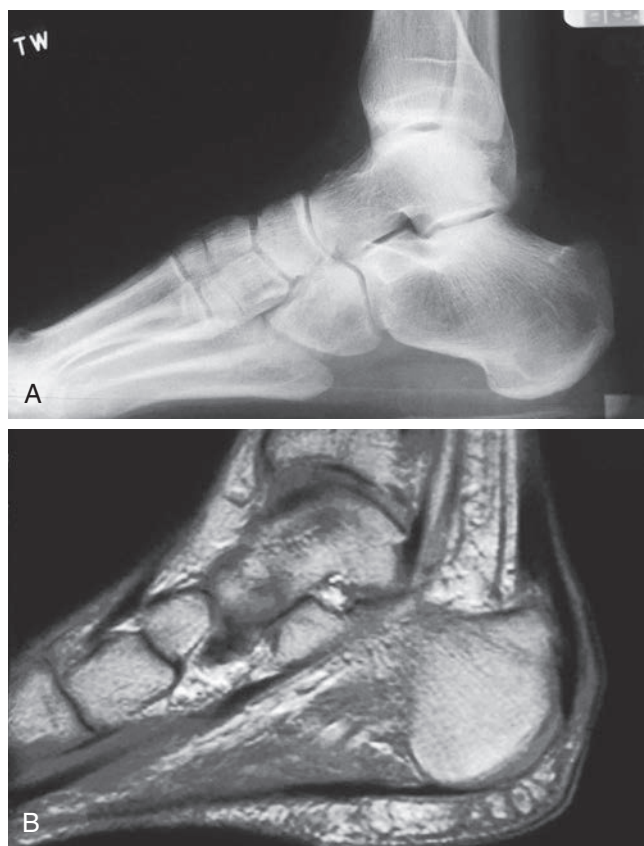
(A) Lateral radiograph of calcaneus demonstrating Haglund's deformity. (B) Sagittal magnetic resonance imaging of the same patient showing changes at Achilles tendon from bony prominence and its effect on Achilles tendon, with thickening and fibrosis as it passes by the bone and more proximally.
